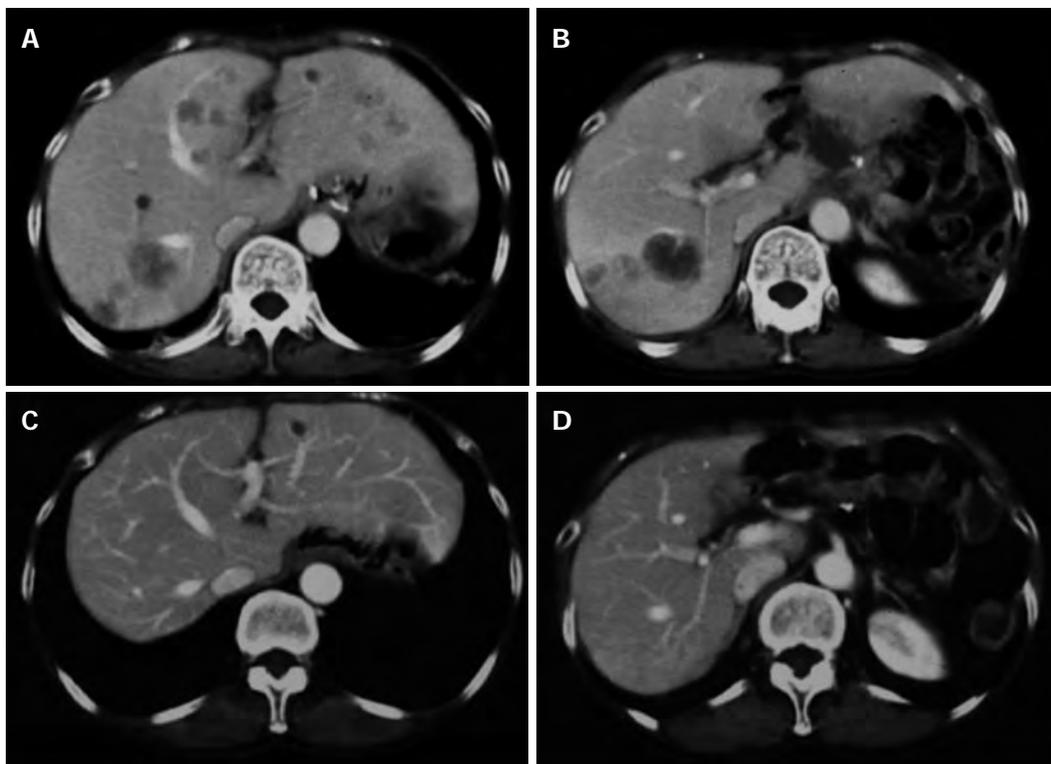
Computed tomography images before and after chemotherapy. A, B: Seven days after surgery, multiple low-density lesions were detected in the liver on abdominal computed tomography; C, D: After three cycles of etoposide, methotrexate, actinomycin D, cyclophosphamide, and vincristine, the tumors disappeared with a clinical complete response.
